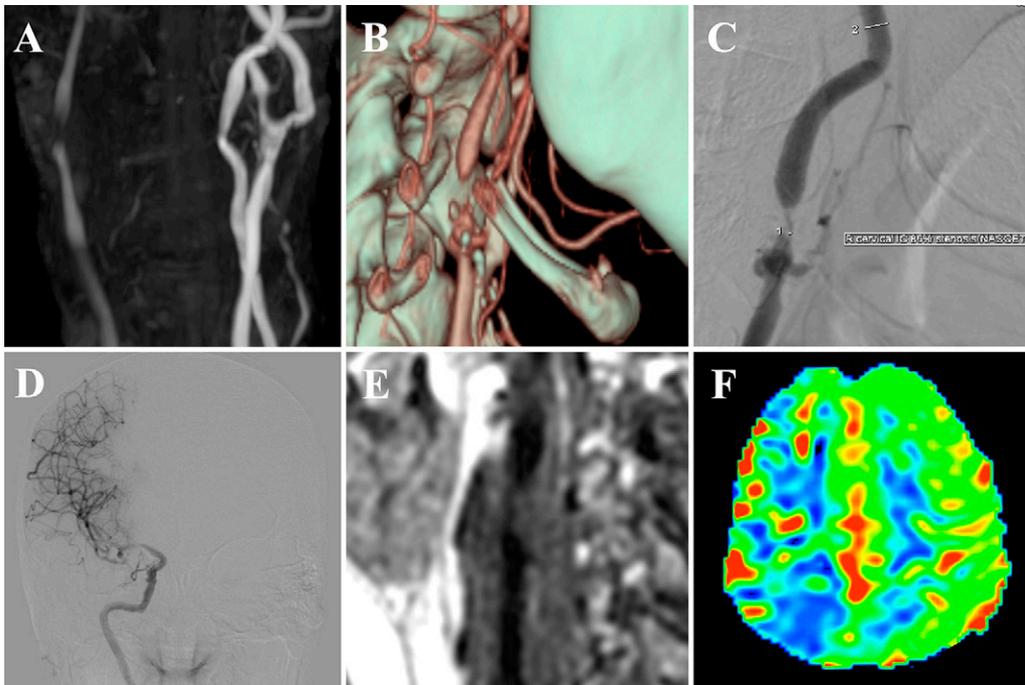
Preoperative imaging. Magnetic resonance angiography (MRA) on admission showing a decreased signal intensity in the right carotid artery, suggesting a stenotic lesion (A). Computed tomography angiography (B) and digital subtraction angiography (C) demonstrate severe stenosis of the right cervical carotid artery. Intracranial aneurysms were not observed on cerebral angiography (D). The plaque is depicted as a partial high-signal intensity on T1-weighted black-blood imaging, suggesting vulnerability (E). Arterial spin labeling (ASL) showing decreased cerebral blood flow in the right middle cerebral artery territory (F).
